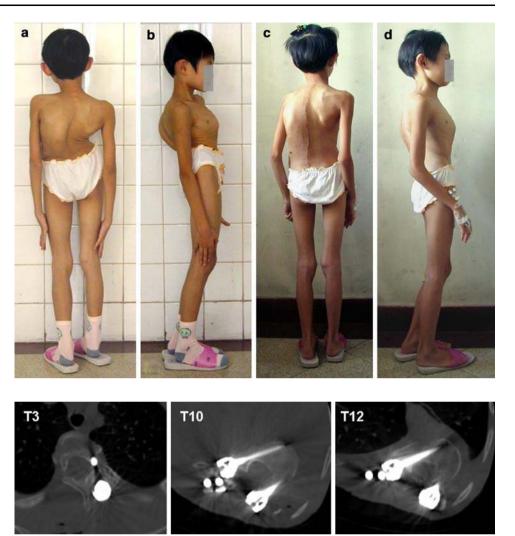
Postoperative CT images showing the pedicle screws in the pedicle tract, without cortical wall perforation
